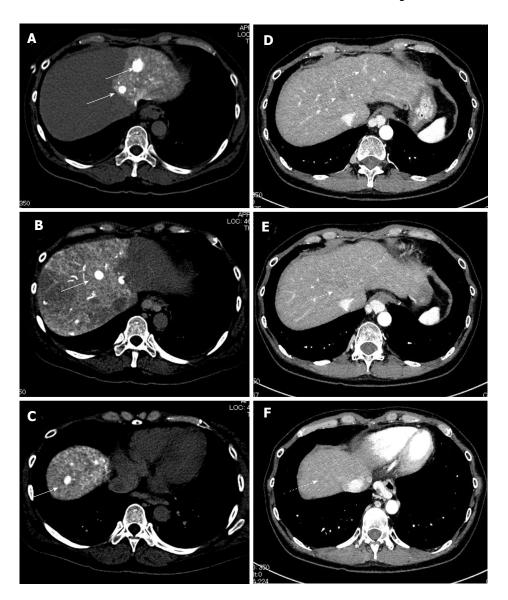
The representative dynamic contrast-enhanced computed tomography images of case 1 before and after eight times of combination therapy. A-C: White arrows indicate tumors before the combination therapy; D-F: White arrows with dotted line indicate the tumor disappearance after eight times of combination therapy.
